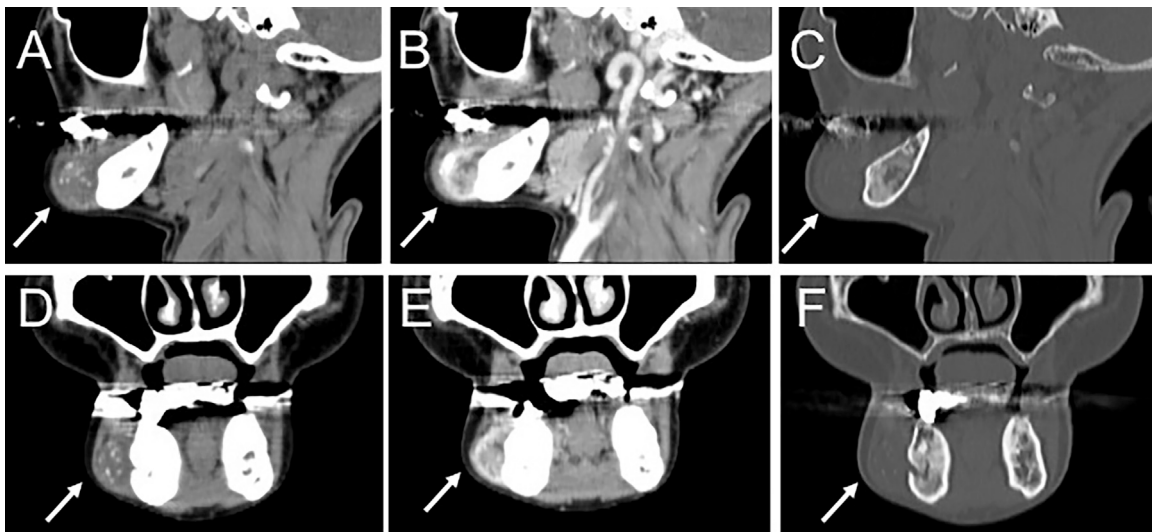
Sagittal and coronal soft tissue algorithm CT (A and D) show a well-circumscribed heterogeneous mass (arrow), buccal to right alveolar ridge. Contrast-enhanced CT (B and E) of mass lesion show heterogeneous (arrow). The bone tissue algorithm CT (C and F) show many calcified foci in the region of the right buccal lesion (arrow). The bone image does not show cortical bone destruction or medullary involvement, and shows sclerosis of the body of the right mandible which was near the parosteal osteosarcoma lesion.
